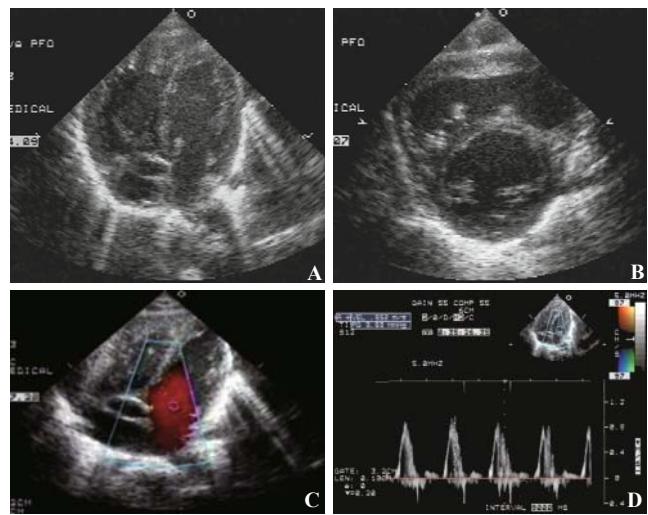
Echocardiogram taken at day one after birth. Four-chamber view indicated reasonable size of left heart (A). Mitral valve opening and structure were considered normal (B). There was no acceleration in left ventricular inflow by color Doppler (C) or pulsed Doppler (D).
